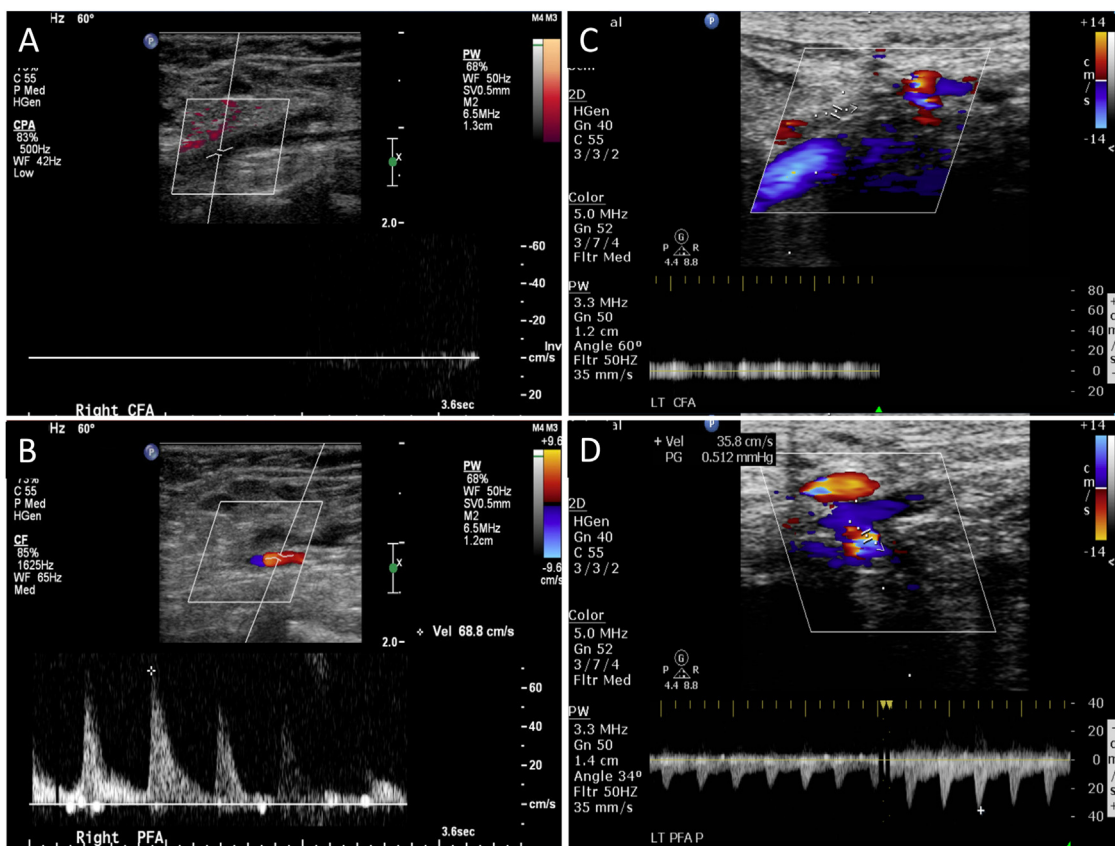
(A) Arterial duplex ultrasonography of an 8-month-old male infant demonstrating the absent flow in the right common femoral artery. (B) The flow in the profunda femoris is antegrade beyond the thrombosed common femoral artery. (C) Arterial duplex ultrasonography of a 7-month-old male infant with a thrombosed left common femoral artery. (D) The flow in the profunda femoris is retrograde beyond the thrombosed common femoral artery.
